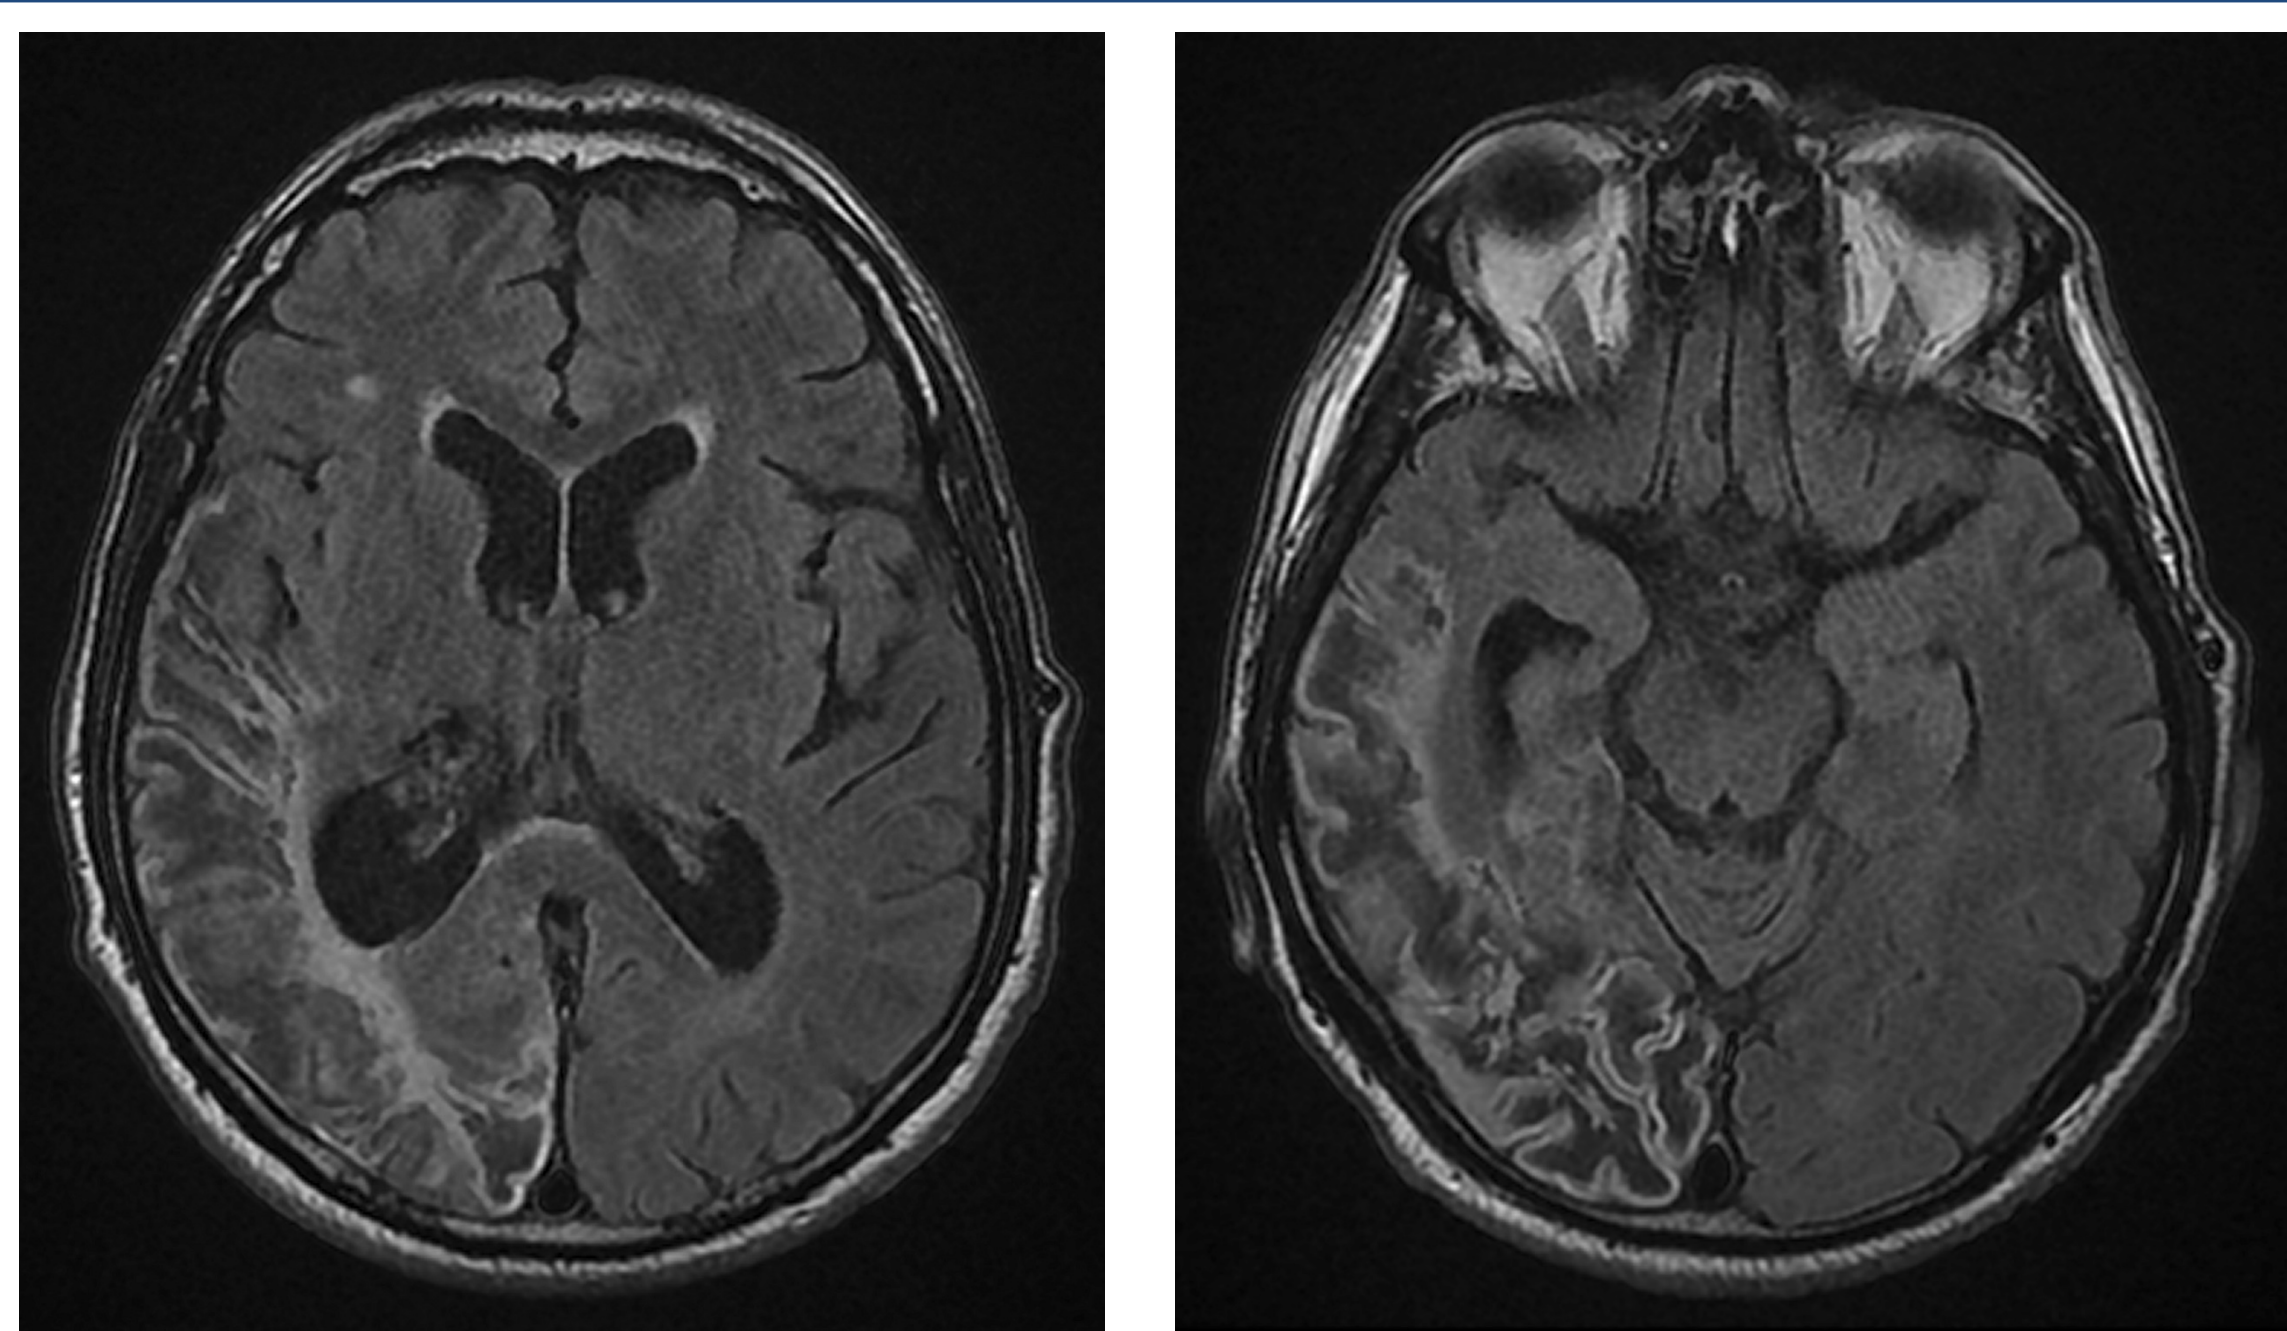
Magnetic Resonance images (MRI).
